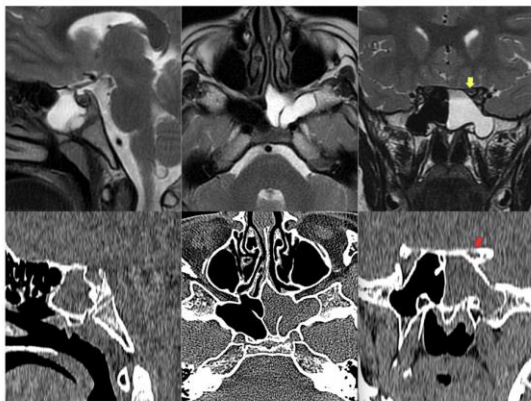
Preoperative MRI and CT show a lesion within the left sphenoid sinus. On CT, there is no bone erosion around the optic canal. Yellow arrow optic nerve, Red arrow- optic canal.
